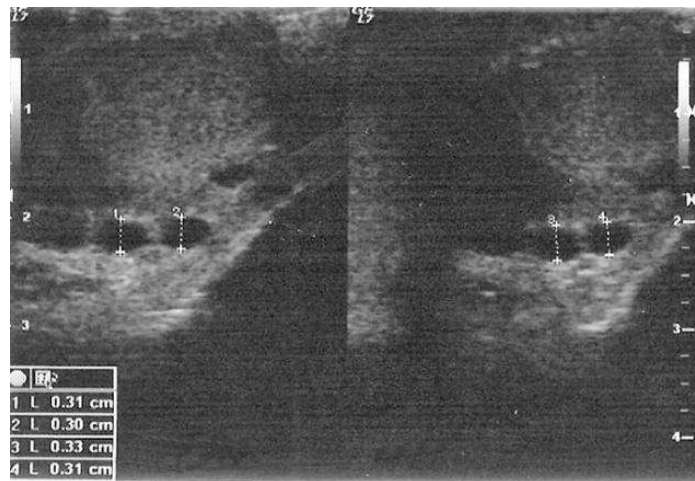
Grade 2 varicocele in a 45 year-old man. Transverse gray scale ultrasound image shows varicose pampiniform plexus veins in neutral position (left). No significant increase in diameter is monitored during the Valsalva maneuver (right).
